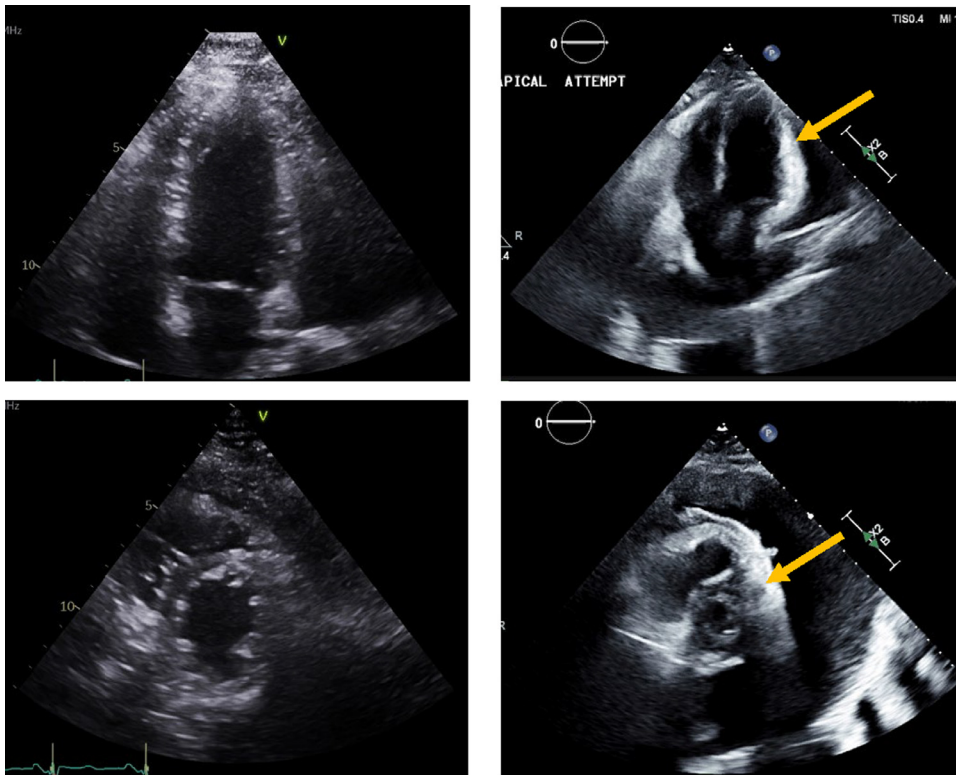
Echocardiography four-chamber views (upper images) and parasternal short axis (lower images) showing off-axis cardiac images and mediastinal fluid after pneumonectomy (images on the right, arrows), compared with prepneumonectomy (images on the left).
